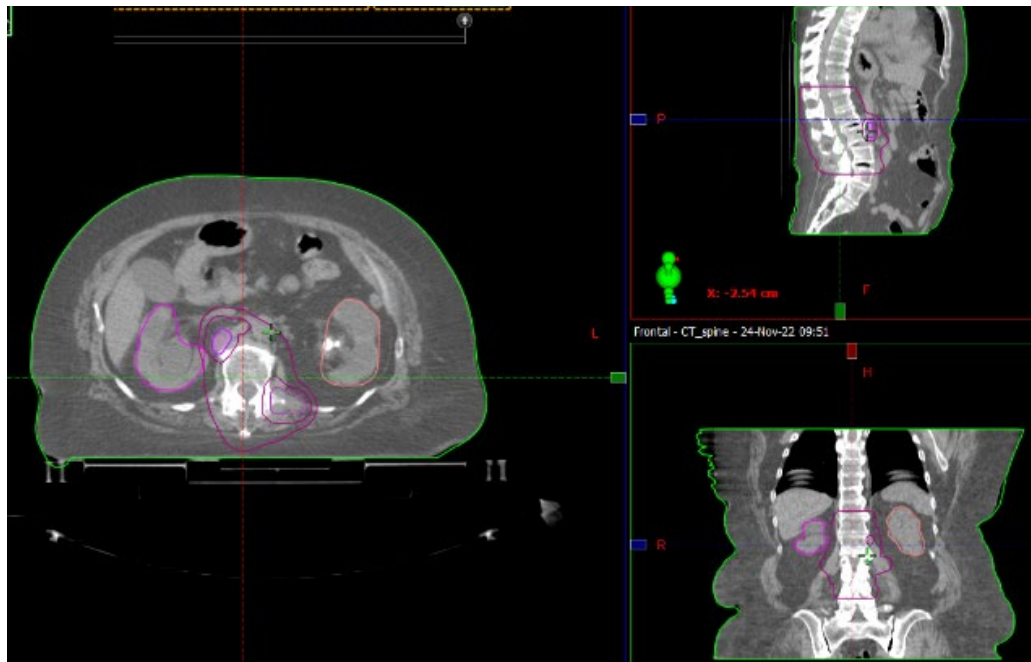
Radiotherapy planning-CT with contouring of the clinical target volumes and the normal surrounding organs and structures.
